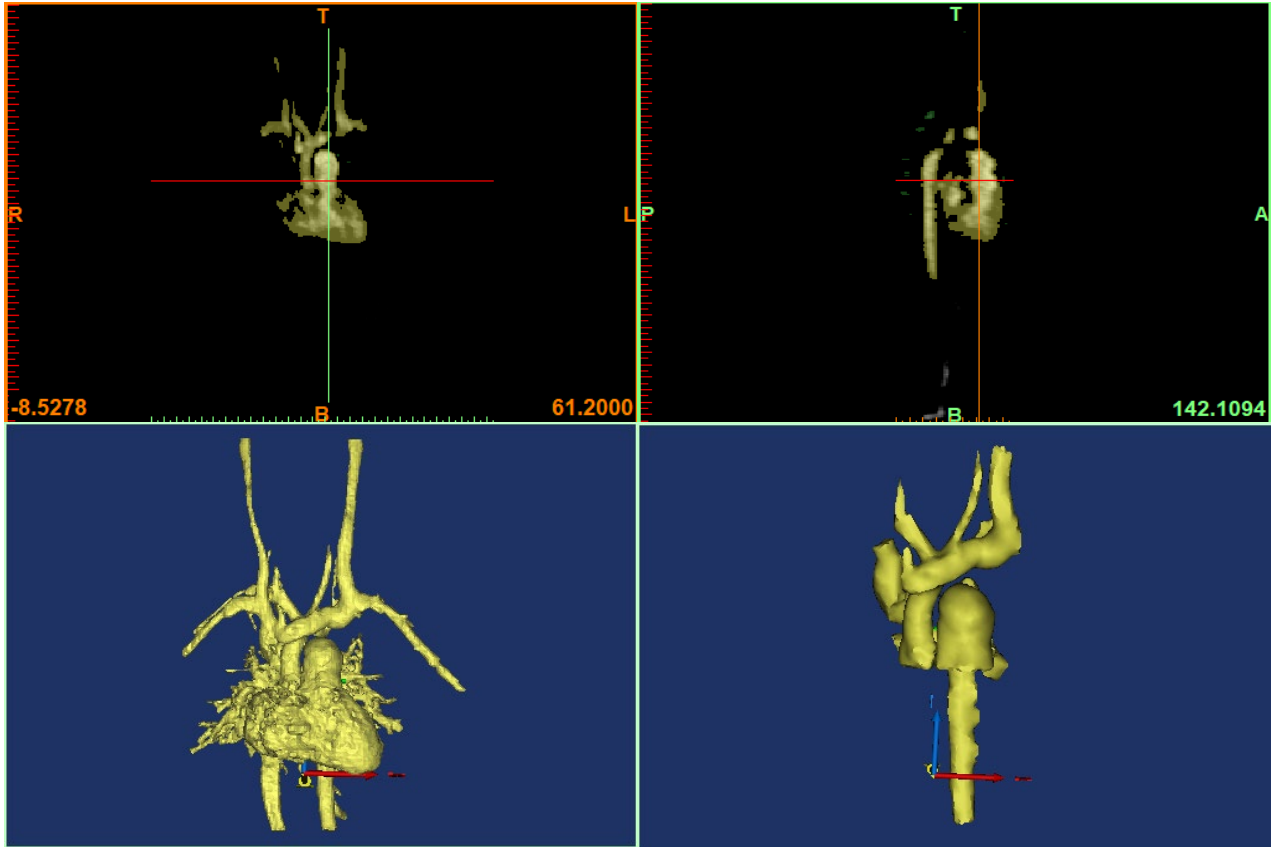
Three Dimensional Patient-Specific Model of a Post-Operative Hybrid Comprehensive Stage II Segmented from MRI Scan
